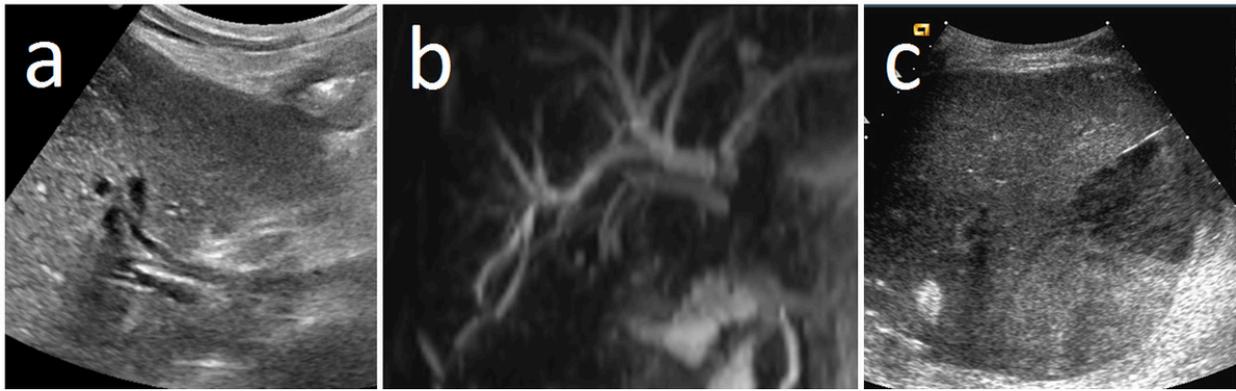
Biliary complications. a) Echography showing a dilatated biliary tree in the hepatic helium in a patient with a biliar stenosis; b) CholangioMRI of the same patient with the dilatation of the biliary tree and the stenosis (arrow) in the anastomosis; c) Ultrasonography showing a subhepatic collection with an echogenic level, corresponding to a biliary leak.
